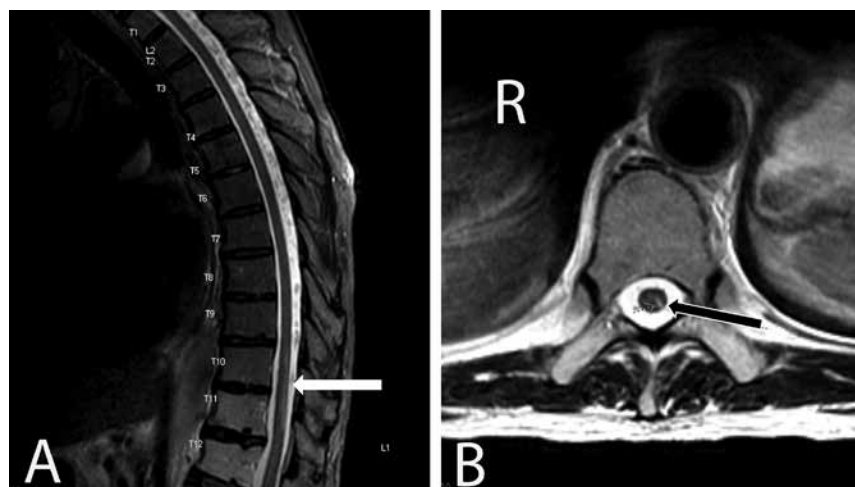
MRI images of thoracic spine with sagittal (A) and axial (B) views. Abnormal signals were detected in the dorsal aspects of spinal cord from T10 to T11, left greater than right (arrows). MRI: Magnetic resonance imaging; R: Right side.
